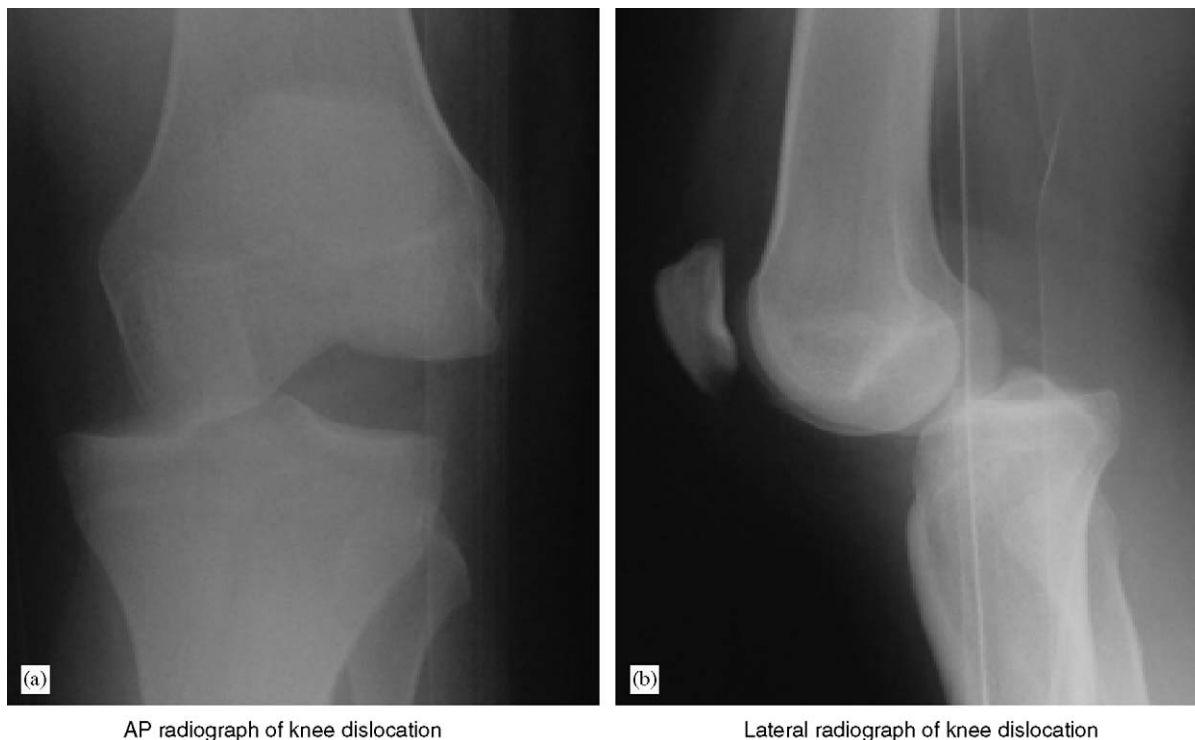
(a,b) Radiograph of postero-medial knee dislocation.
